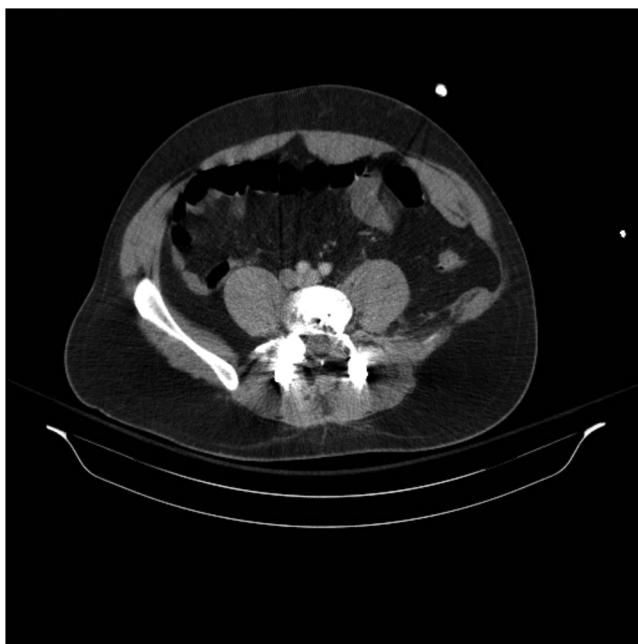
Axial CT with evidence of left-sided traumatic flank hernia and no associated intra-abdominal injuries after motorcycle collision.
